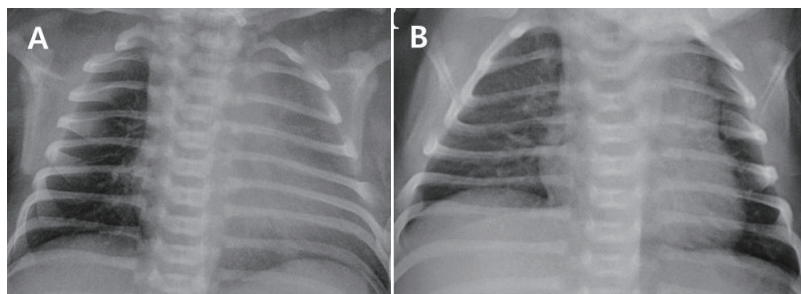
Chest posterior-anterior (PA) radiograph. A: Chest PA radiograph at birth shows severe cardiomegaly with a cardiothoracic (CT) ratio of 66.2%. B: Chest PA radiograph at 2 weeks after birth shows that the heart shadow has regressed to normal with a CT ratio of 46.7%.
